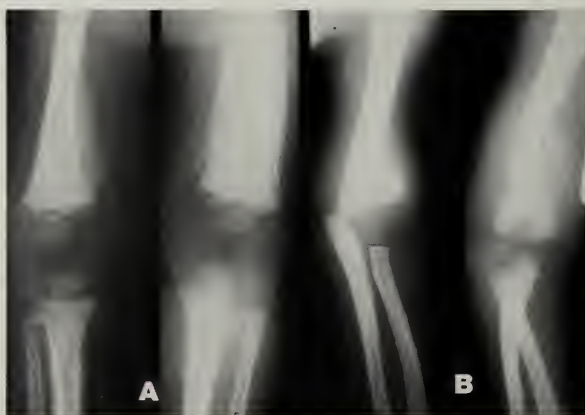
This 10-month male was admitted with multiple bruises. Radiographs of the lower extremities (A), right (R), and left (L); and the upper extremities (B), right (R) and left (L) showed multiple fractures of varying age. Exuberant subperiosteal new bone formation is seen on both distal femora and band-like metaphyseal irregularity in distal femoral and proximal left tibial metaphyses. A diagnosis of child abuse was established.
